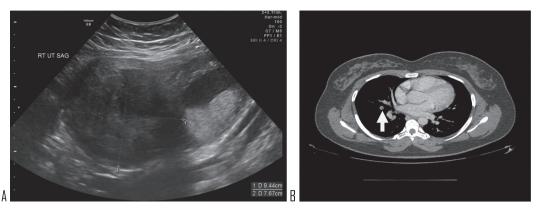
A. Ultrasound image uterine fibroid at 24 weeks gestational age. B. CT chest at 13 months after cesarean hysterectomy (arrow points to pulmonary nodule).
